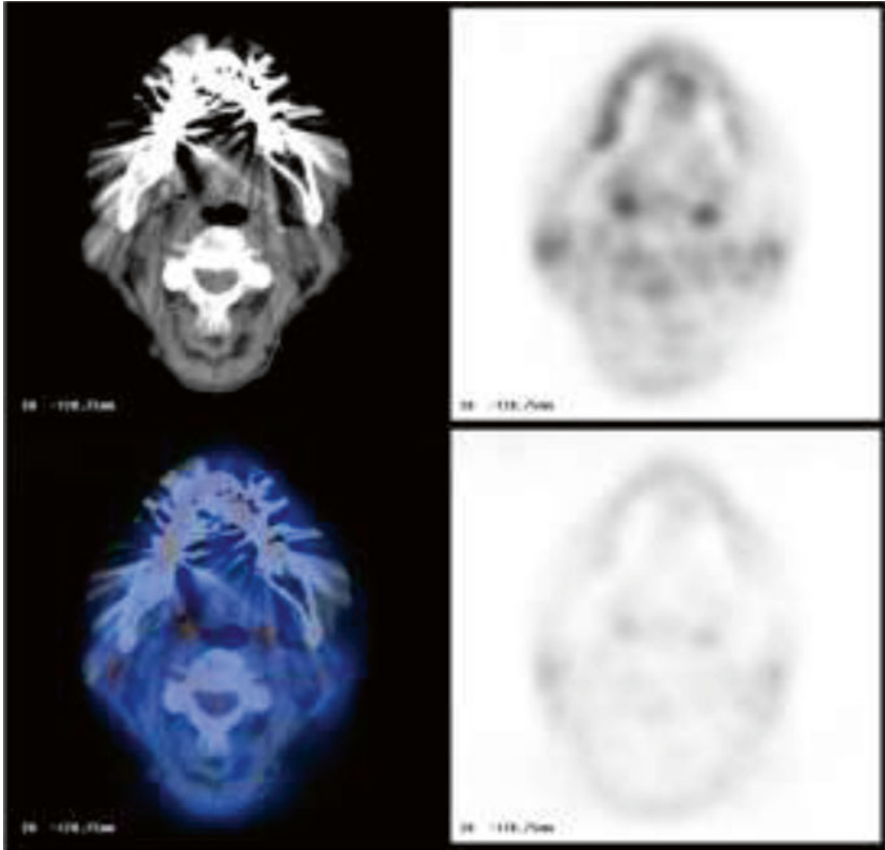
Beam hardening artefacts on CT caused by dental amalgam. PET quantification and localisation can be difficult although non-attenuation corrected data (*bottom right panel*), may help with identifying artefacts in the attenuation corrected images (*top right panel*)
